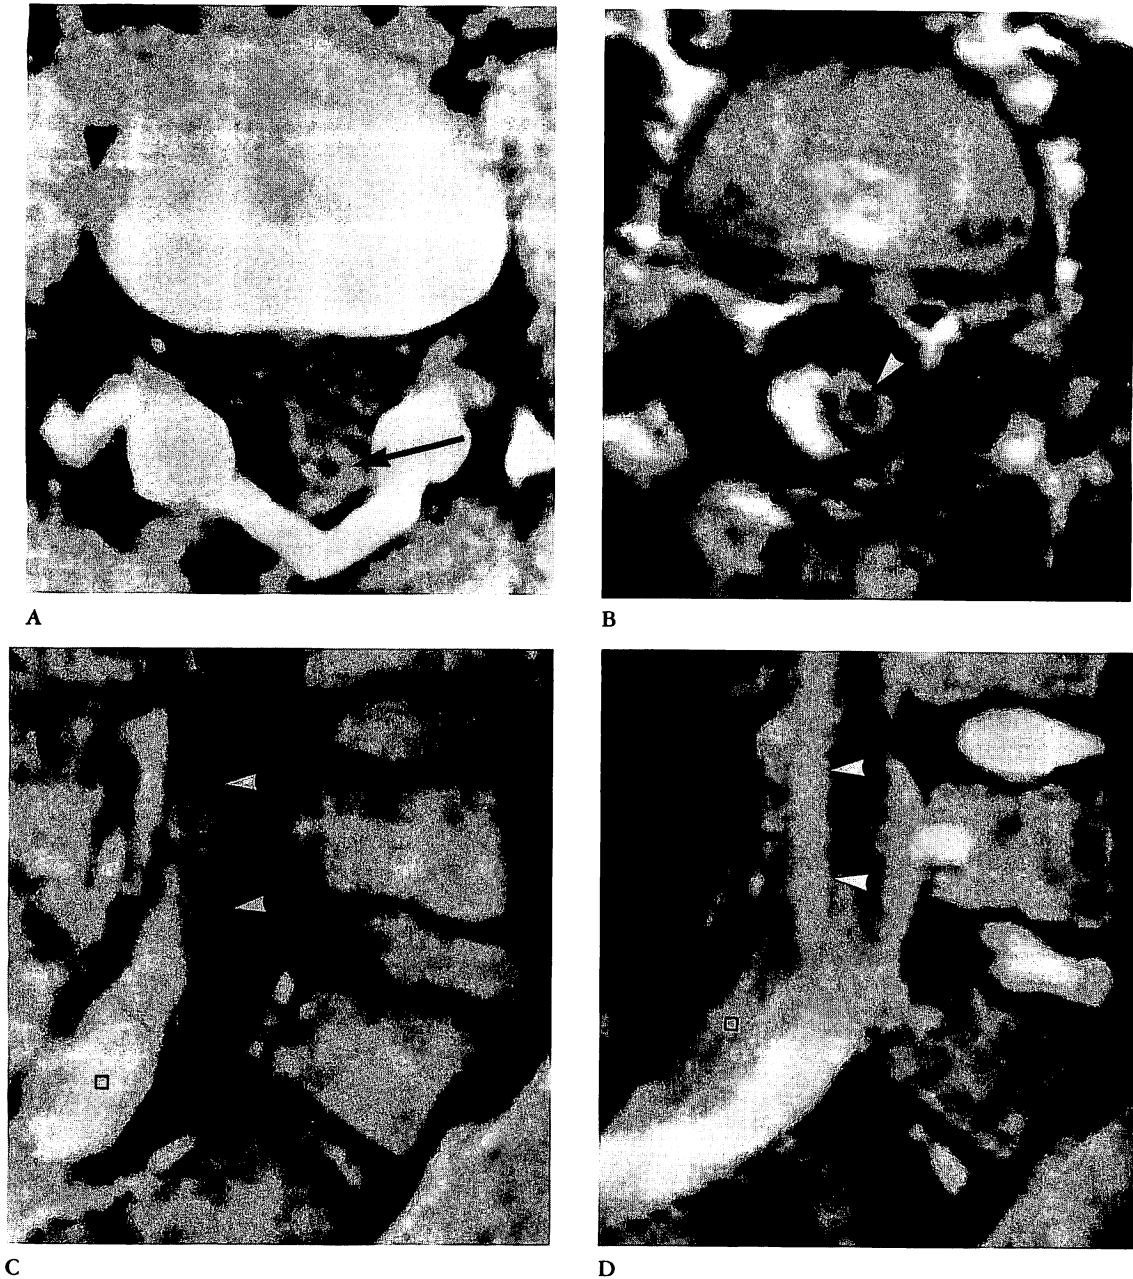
Case 2: A preoperative 3-year-old girl with LS lipoma. (A) Noncontrast CT demonstrates low attenuation of the lipoma at the L-5 level. Tethered spinal cord (arrowheads) is vaguely discernible at the anterolateral aspect of the lipoma. (B) Axial T1-weighted SE image clearly discloses both lipoma and spinal cord (circle). Note the low intensity band (arrowheads) due to chemical shift at the anterior aspect of the lipoma. Direction of frequency-encoding gradient (arrow) is from patient posterior to anterior. Lipoma image shifts in the direction opposite that of the frequency-encoding gradient.
